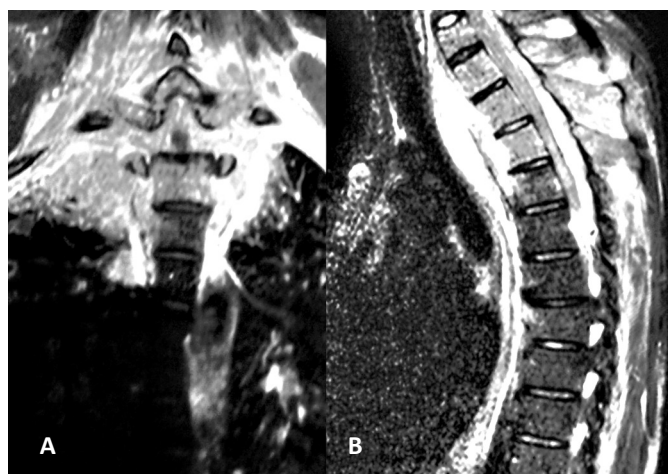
Magnetic resonance imaging with coronal (A) and sagittal (B) reconstructions. The image shows an infiltrative mass that affected the vertebral bodies, elements of the upper thoracic and lower cervical posterior arches, ribs, and paravertebral soft tissue, with involvement of the spinal canal.
